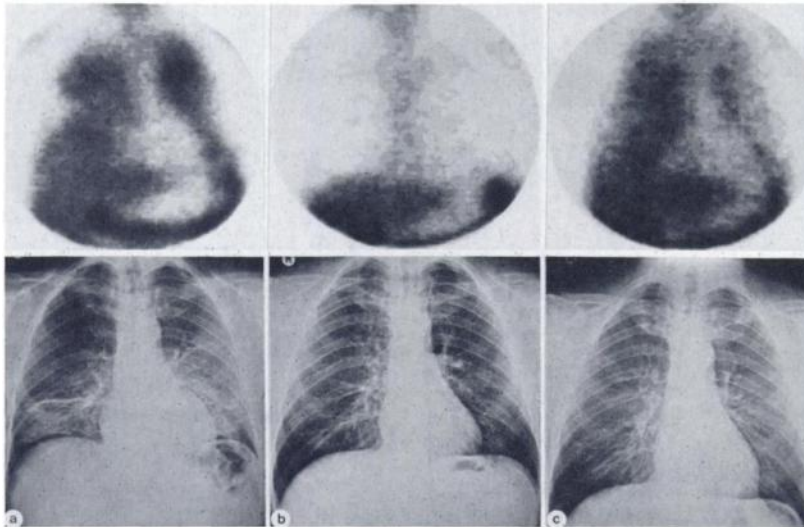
Case 2: Anterior Ga-67 lung scintigrams (above) and chest radiographs (below): (a) intense diffuse Ga-67 activity on amiodarone treatment; radiographs shows ground-glass pattern and segmental collapse in both lungs; (b) after instigation of prednisolone treatment (40 mg daily), Ga-67 image and radiographs become normal; (c) after reduction of prednisolone dosage, Ga-67 uptake is intense, but radiograph is unchanged.
